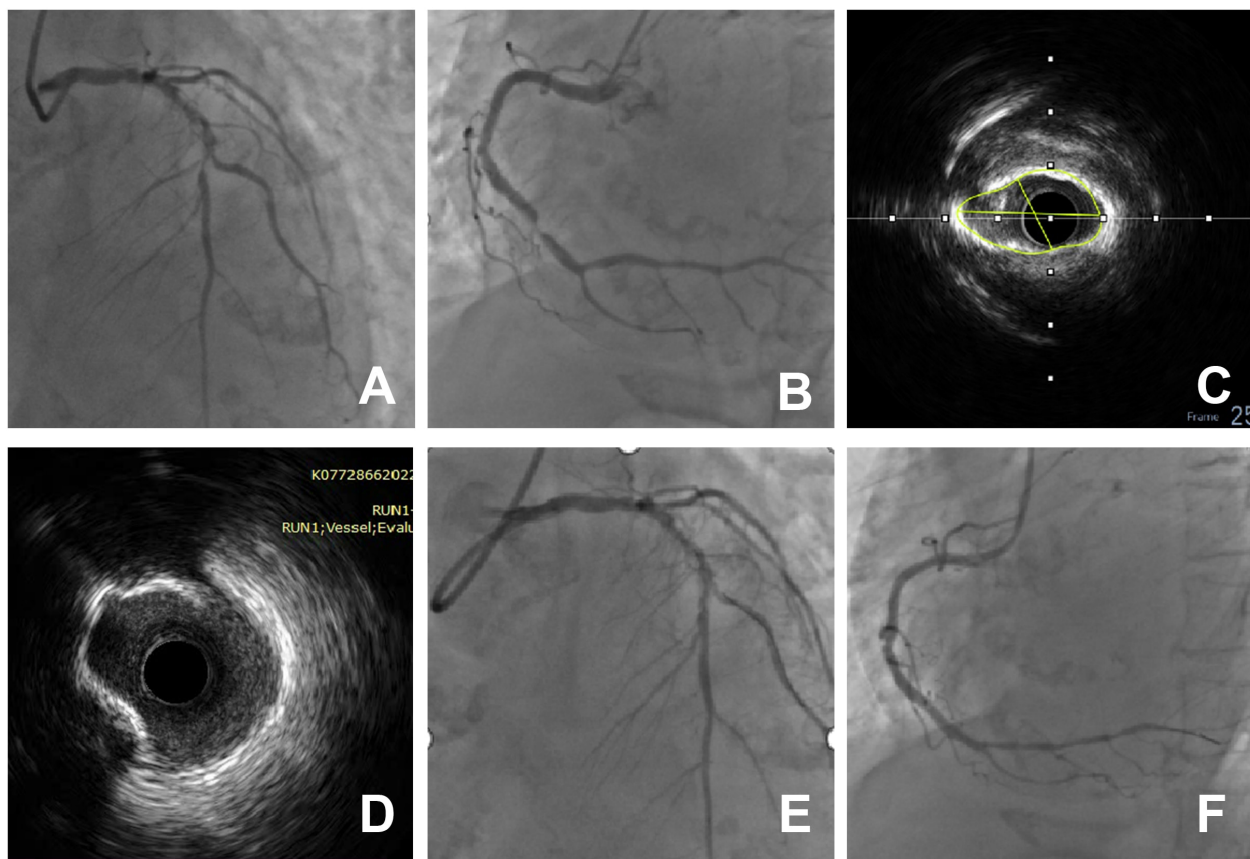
Coronary angiography findings and intervention. (A) Left coronary angiography revealed diffuse calcification with severe stenosis extending from the left main coronary artery to the proximal left anterior descending (LAD) artery. (B) Right coronary angiography identified a severe stenosis in the distal segment of the vessel. (C,D) Intravascular ultrasound (IVUS) interrogation revealed a minimal lumen area (MLA) of 3.1 mm² at the LAD ostium and 4.8 mm² in the left main trunk, with predominantly calcified fibrotic plaque from the left main to the LAD. (E) Balloon angioplasty was performed on the LAD using a 2.0 × 15 mm balloon. (F) A 3.5 × 18 mm drug-eluting stent was successfully deployed in the right coronary artery.
